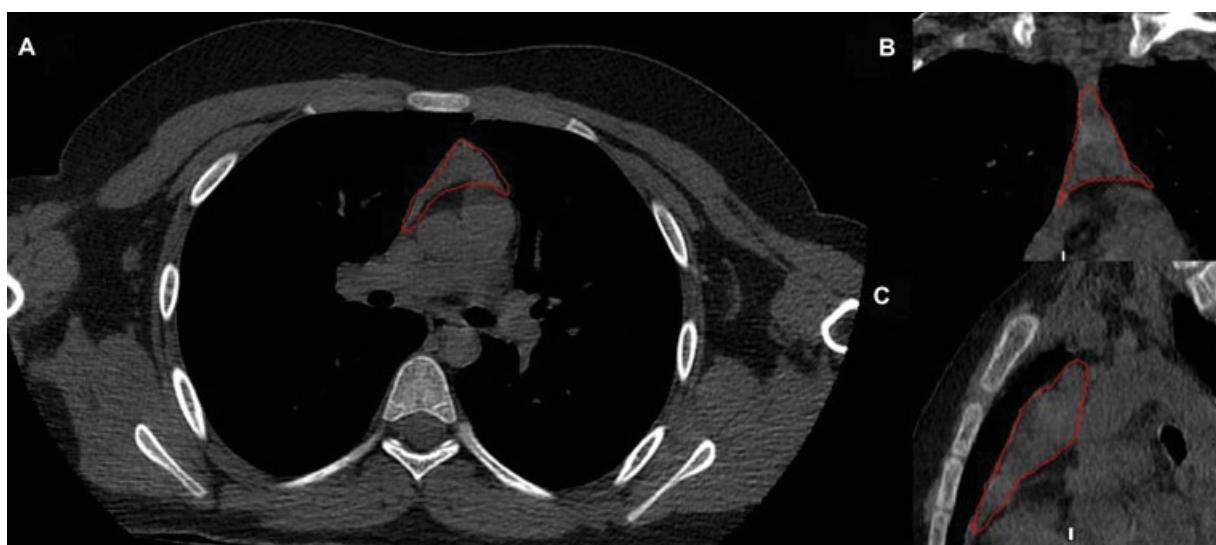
Segmentation of the thymus gland in the axial (A), coronal (B), and sagittal (C) planes on noncontrast thoracic CT scans. CT, computed tomography.
